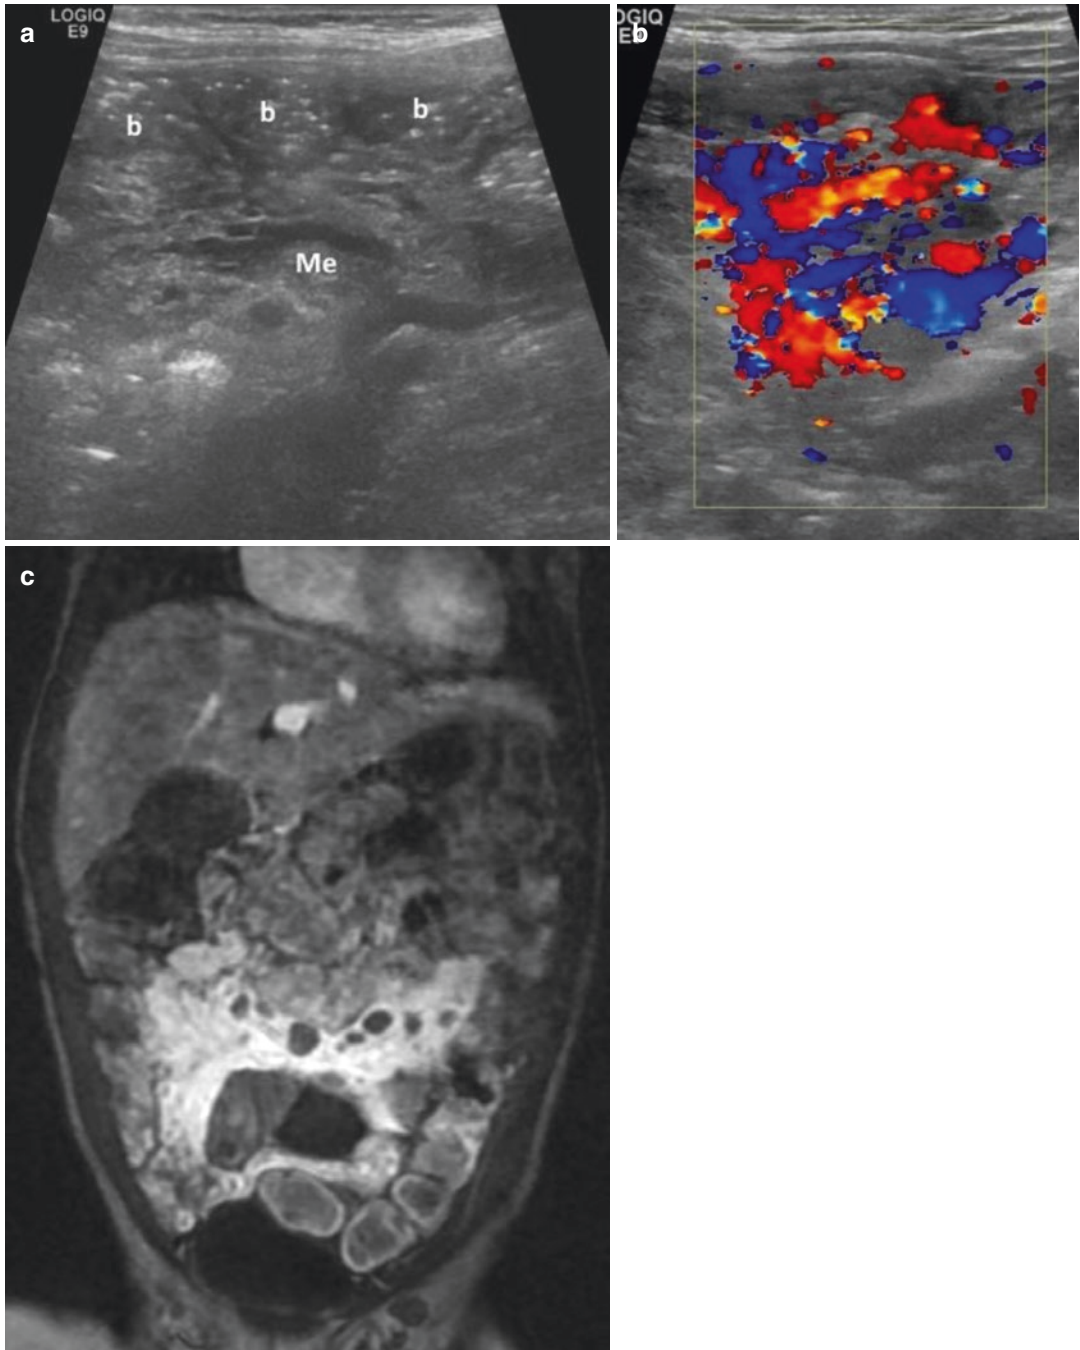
Mesenteric hemangioma in a 2-year-old girl. (a) US—Mid-abdomen scan—thickened mesentery with large vessels. (b) Color Doppler—impressive hypervascularization. (c) MR imaging—T1-weighted post Gd—Important hypersignal of the mesentery. Signal voids due to enlarged vessels
